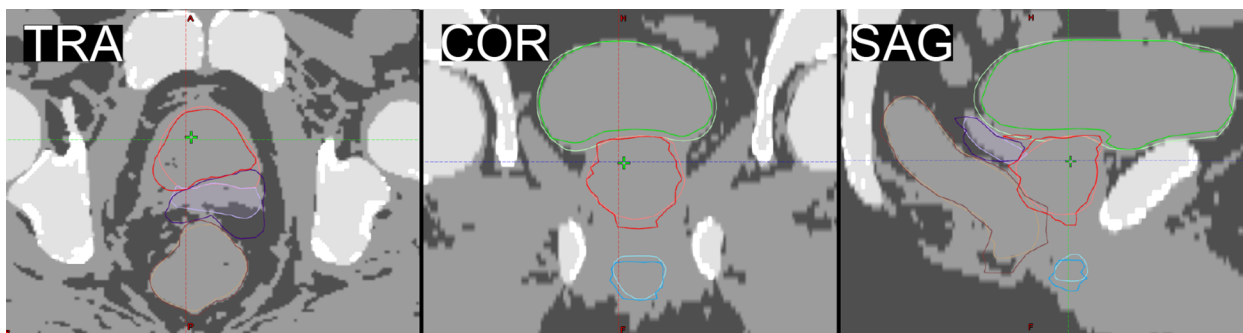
A good example of different delineations between automatic segmentation tool (AST) and clinical investigator (CI) on synthetic CT. Colors (light/dark for AST/CI) and DSC (dice similarity coefficient) for delineations are as follows: prostate (red, 0.86), bladder (green, 0.92), rectum (brown, 0.88), penile bulb (blue, 0.80), and seminal vesicles (purple, 0.76). (For interpretation of the references to colour in this figure legend, the reader is referred to the web version of this article.)
